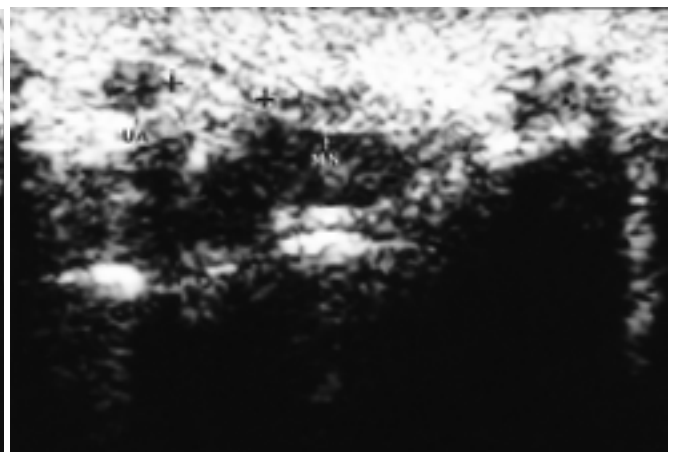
A 52-year-old woman with carpal tunnel syndrome. Axial sonogram at hook of hamate level shows increased palmar bowing of flexor retinaculum. Palmar displacement of flexor retinaculum is measured as 4.1 mm. PD:palmar displacement.
